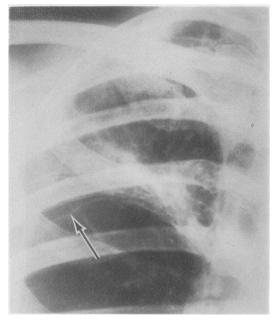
Radiograph showing right upper lobe shrinkage. Arrow points to the small fissure.
